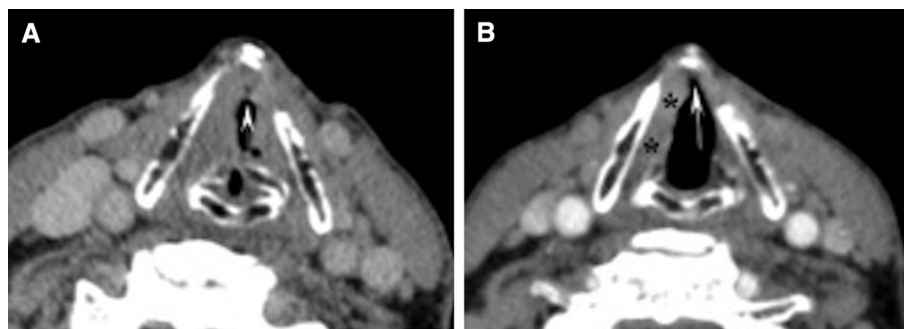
Contrast-enhanced axial plane computed tomography images of a 59-year-old man evaluated for glottic carcinoma. (A) On the images obtained in a neutral position, neither the limits nor the original side of the glottic mass is identifiable. Involvement of the anterior commissure cannot be assessed (arrowhead in center). (B) On images obtained during inspiration, the mass is seen involving the right vocal cord (asterisks), with no extension to the anterior commissure (white arrow).
